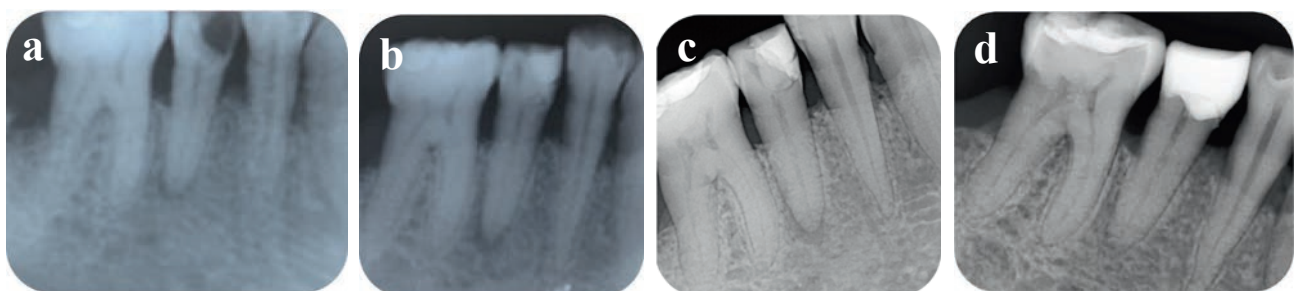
Periapical radiographs: (a) preoperative; (b) after treatment; (c) 6 months postoperative; (d) 12 months postoperative.
